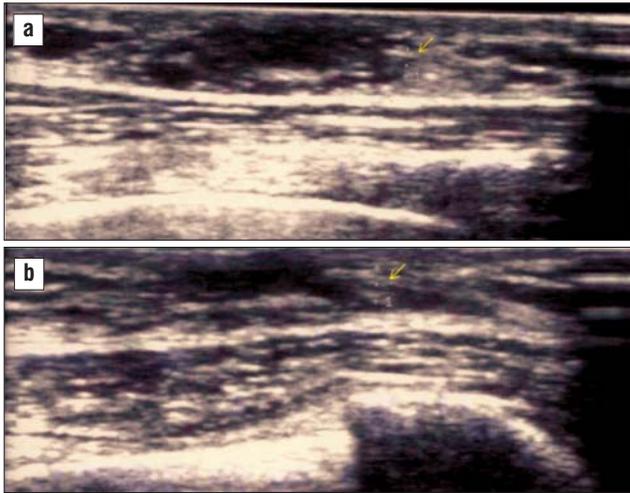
Bilateral breast ultrasound showing lack of gynecomastia in a adult hypogonadic male: breast tissue of 0.3 cm on the right, of 0.2 cm on the left side (arrow)
